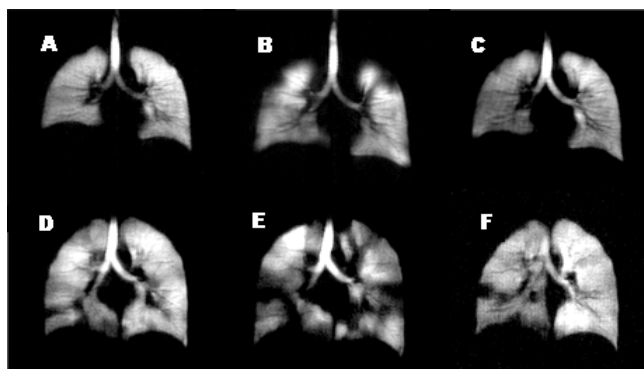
Hyperpolarized ³He MRI of asthmatic lungs of two subjects at baseline (A and D), after methacholine challenge (B and E) and after recovery (C and F).
